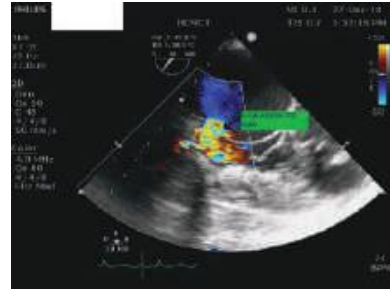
2D-Transesophageal echocardiogram in the Mid-esophageal 5 chamber view demonstrating flow into the right atrium through the defect.
